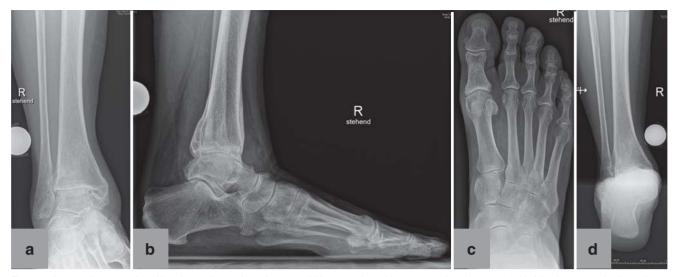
Preoperative conventional X-ray in standing position of 67-year-old female patient with posttraumatic ankle osteoarthritis following open reduction and internation fixation for trimalleolar luxation fracture 4 years earlier: a) mortise view of ankle; b) lateral view of foot and ankle; c) dorsoplantar view of foot; d) Saltzman view of hindfoot
